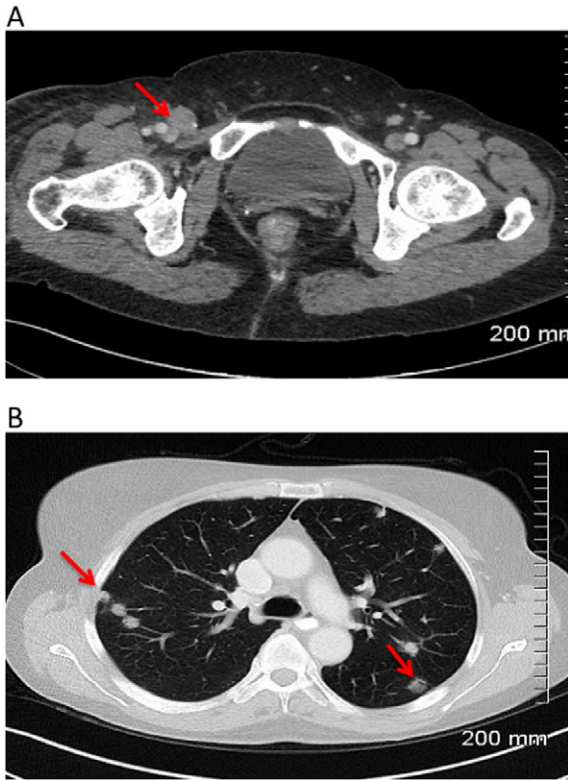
(A) Axial contrast enhanced CT through the lower pelvis demonstrates a 2.5 cm distal right external iliac lymph node. (B) Axial CT image through the mid thorax on lung windows demonstrates multiple rounded nodules, imaging features consistent with pulmonary metastases.
